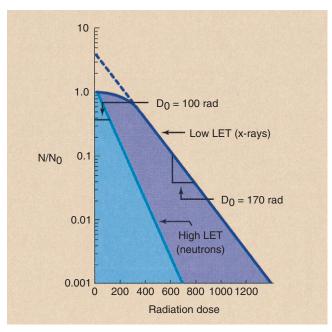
Representative cell-survival curves after exposure to 200-kVp x-rays and 14-MeV neutrons.
